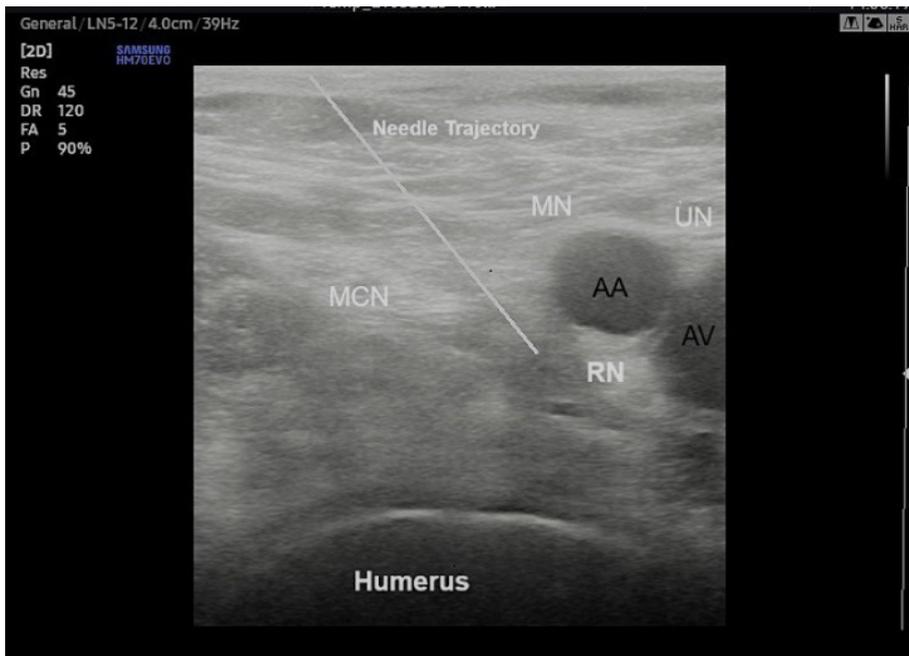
Ultrasonographic image of axillary brachial plexus block
